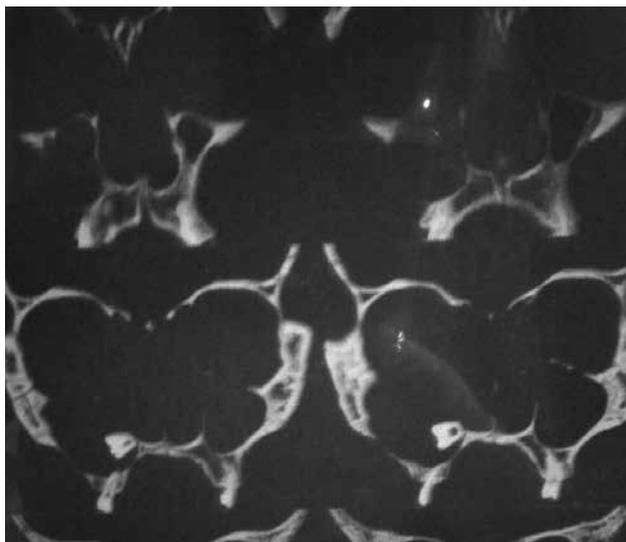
CT image showing the dentigerous cyst in the right maxillary sinus.
